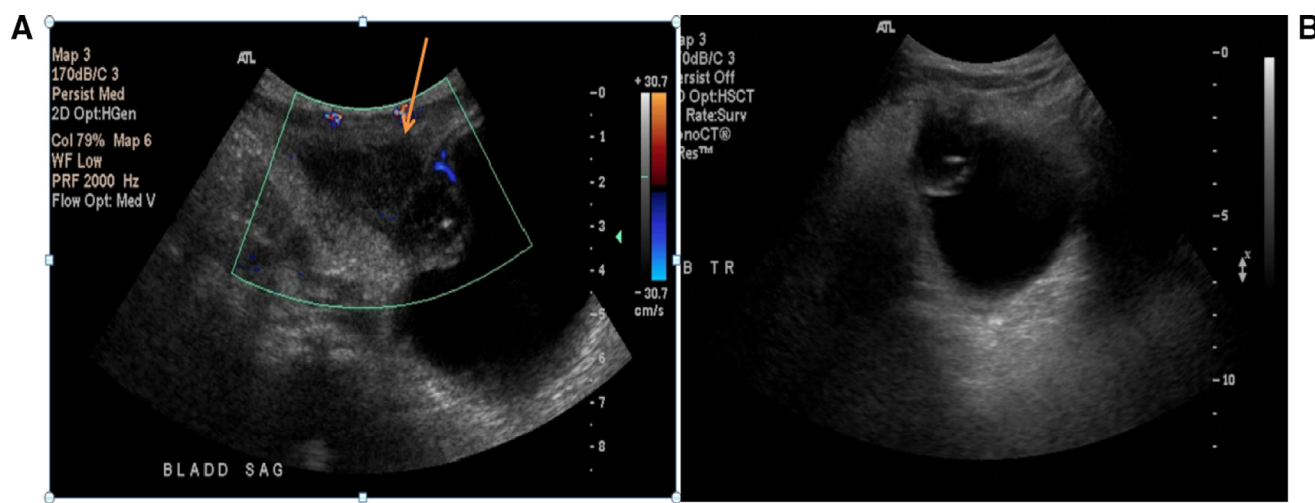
Midline sagittally oriented images at the level of the bladder dome obtained during ultrasound of the abdomen and pelvis utilizing color Doppler and grayscale images. (A) Heterogeneous lesion extends superiorly from the bladder dome lacking internal vascularity. This was a key finding in distinguishing neoplasm from an inflammatory reaction. (B) Intravesicular echogenic lesion abutting the bladder dome; this was felt to represent the extension of the inflammatory reaction into the bladder lumen rather than an intrinsic bladder wall lesion.
